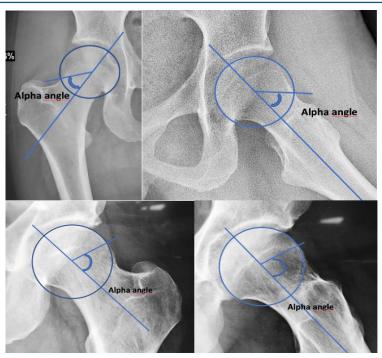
Calculation of the alpha angle in a normal and pathological hip in a X-ray study (Nötzli 2002 JBJS).
